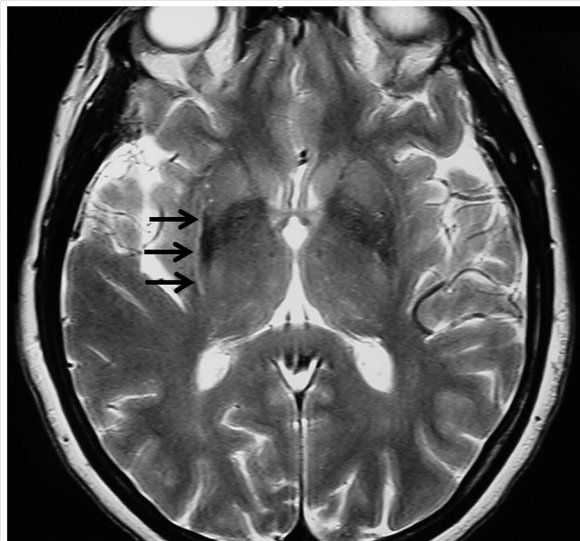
Axial T2-weighted brain MRI of a patient with multiple system atrophy-parkinsonism demonstrating a slitlike area of hyperintensity bordered by hypointensity (from iron deposition) in the putamen, worse on the right (*arrows*). The putaminal atrophy is always greater on the opposite side of the more affected hemibody.
